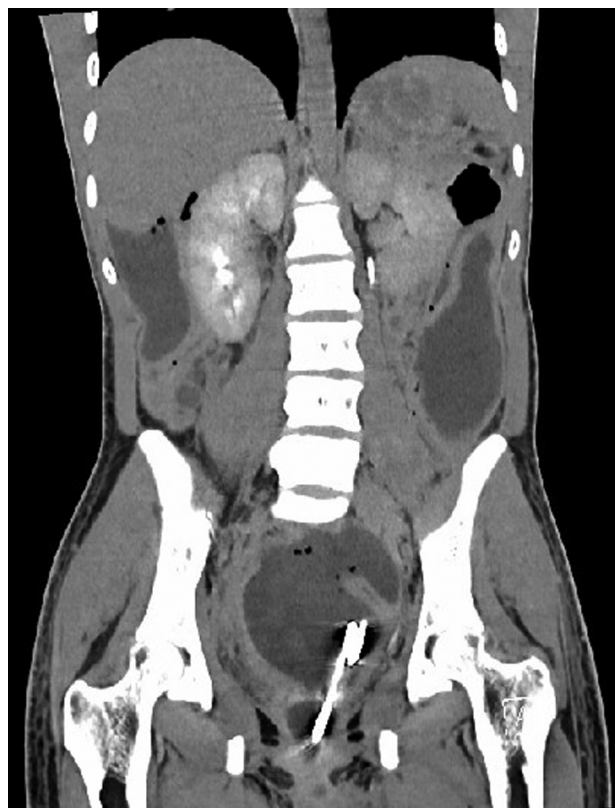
Abdominal CT: multiple intra-abdominal fluid collections (coronal view). CT=computed tomography.
